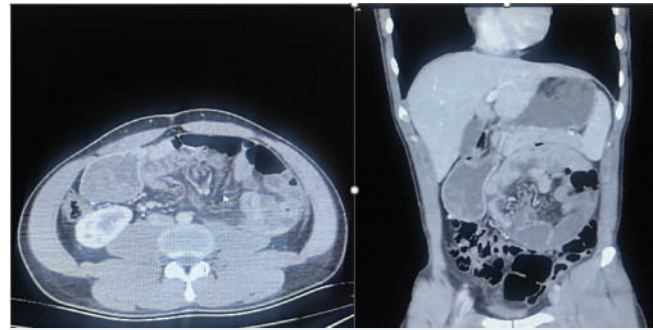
Abdominal CT scan. CT image of internal herniation.
